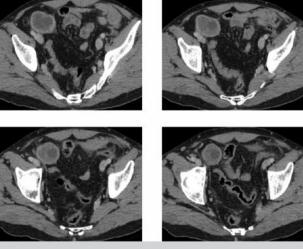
CT sections showing hydatid cyst located in the neighborhood of the inferior part of the cecum
